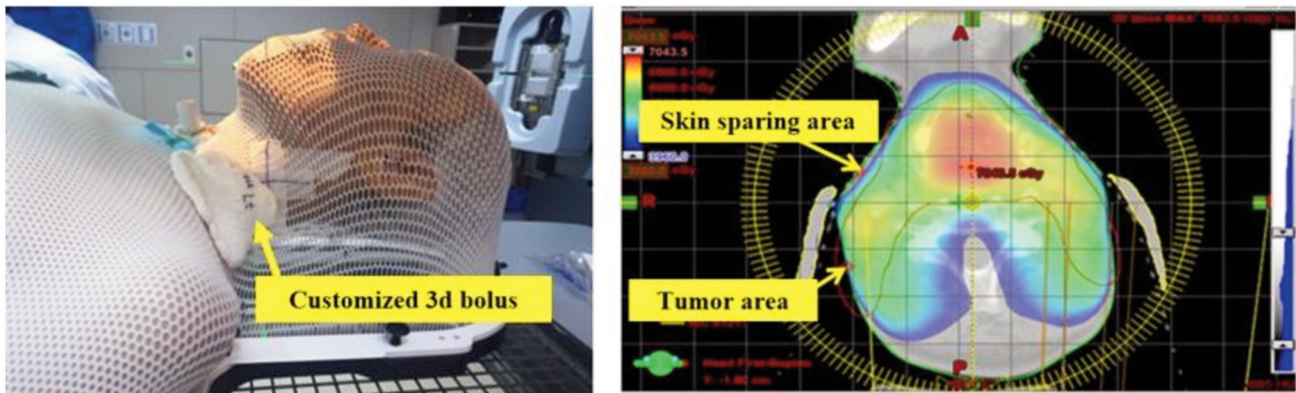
Treatment setup and dose distribution in the treatment planning for patient 1. (a) Patient 1 is an H&N cancer patient. A customized 3D bolus was created for dose buildup in the area where the tumor was adjacent to the skin and attached to the mask for immobilization during the treatment. Since the customized 3D bolus was created based on the patient's CT, it fits well with the patient's body. The same area viewed as an axial image in the treatment plan is shown in (b). The region below the customized 3D bolus is the buildup area in the axial image, and the area without the bolus is the skin sparing area.
